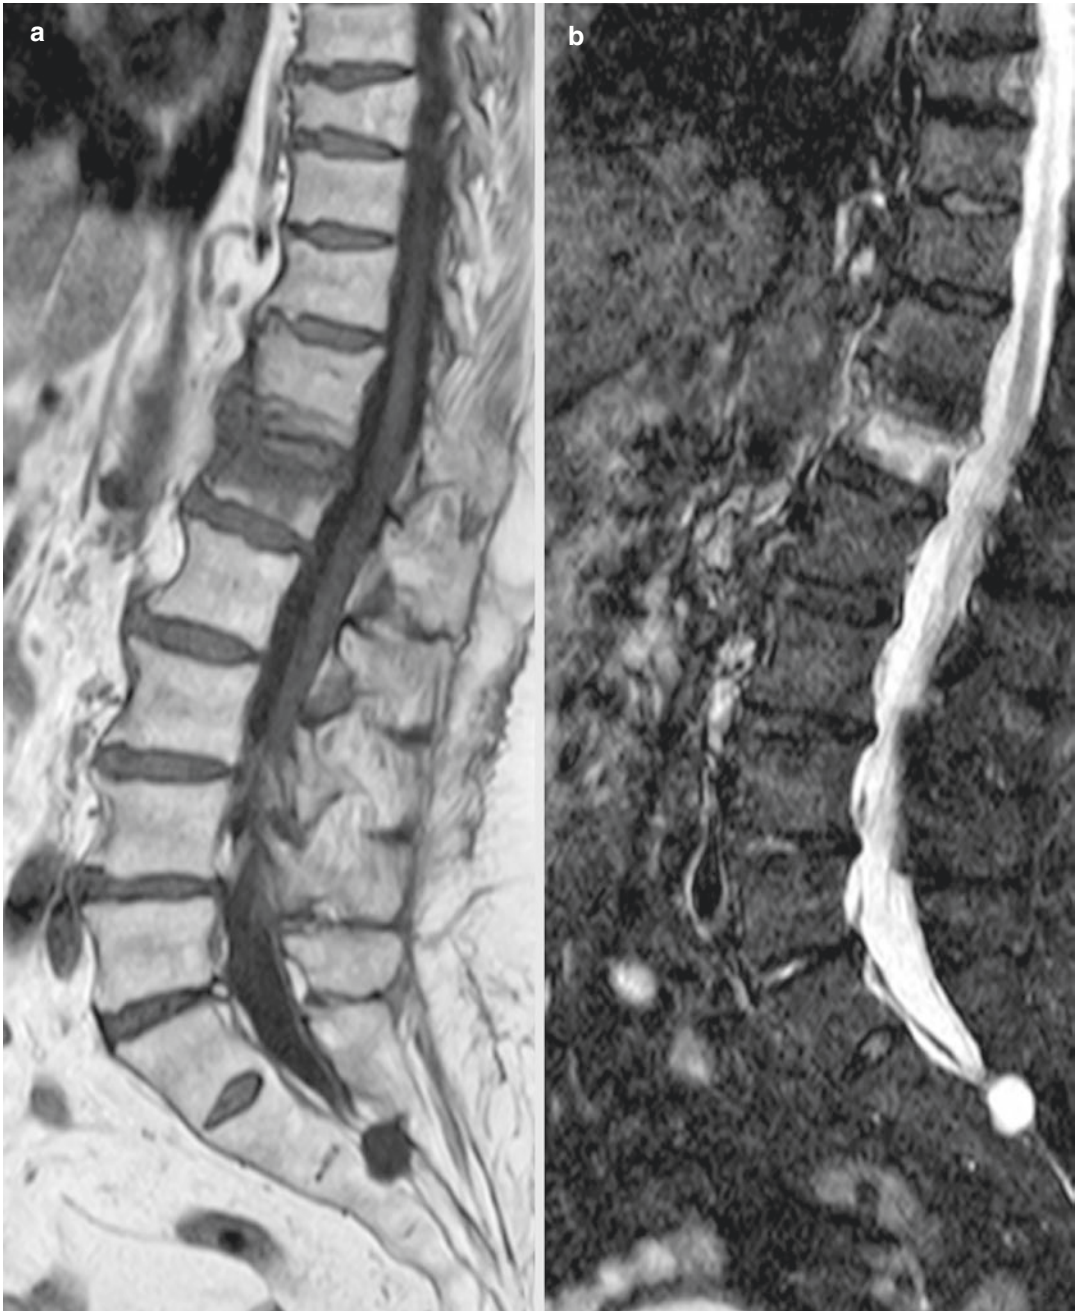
(a) Sagittal T1-weighted MRI shows a vertebral porotic fracture at the L1 level with hypointense signal. (b) Sagittal STIR MRI shows the hyperintense signal due
